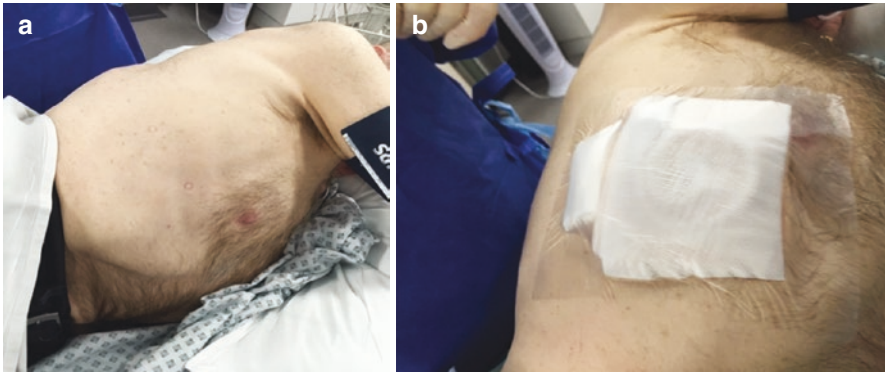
(a) Patient in position whose skin has been marked for ultrasound-guided insertion of indwelling pleural catheter. (b) Indwelling pleural catheter in situ
